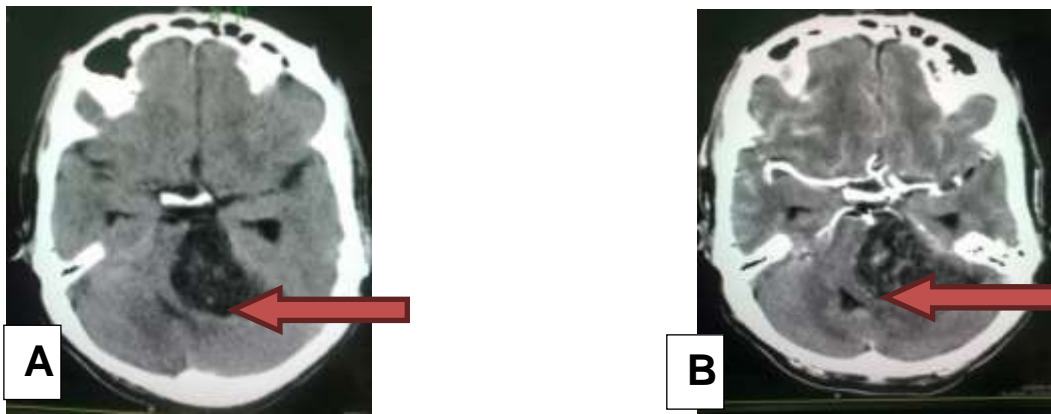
CT Axial Brain image shows a mixed lesion in the left cerebellar hemisphere crossing the midline Arrow A. without contrast. B. with contrast enhancement. Astrocytoma.
